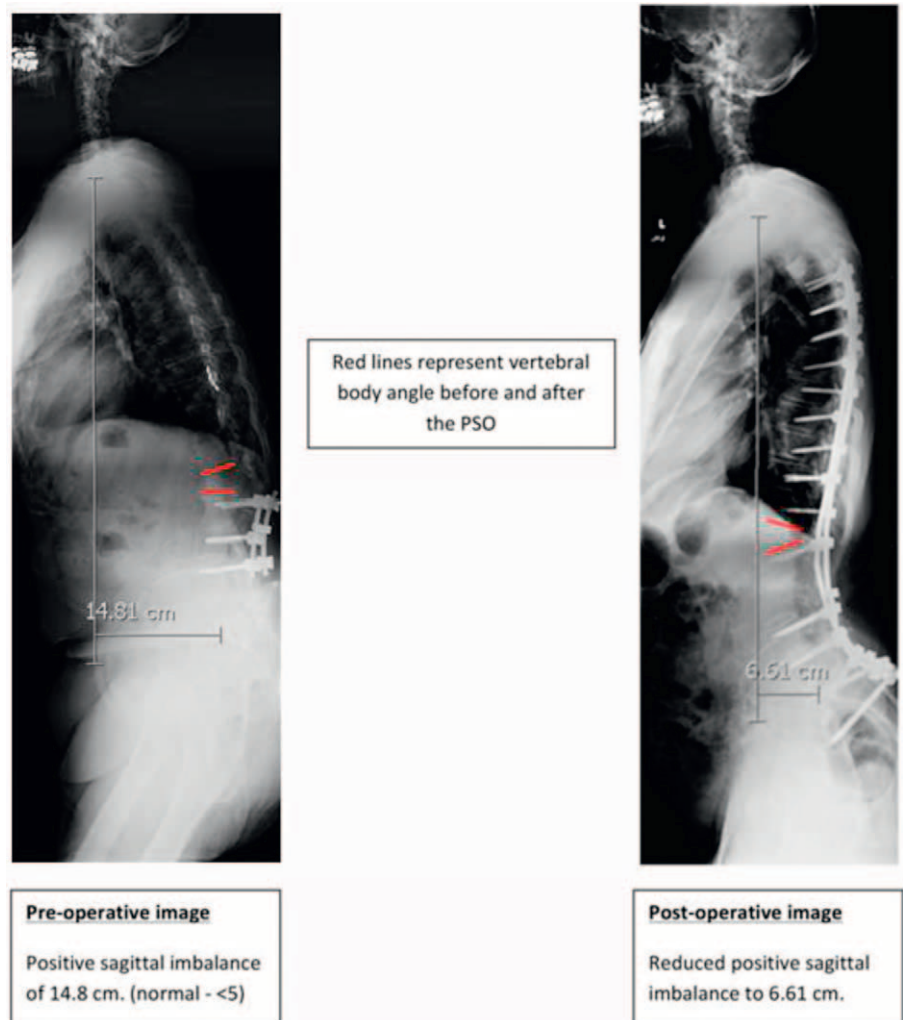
Depicts the presurgical and postsurgical lateral full length standing radiographs with positive sagittal imbalance measurements.
